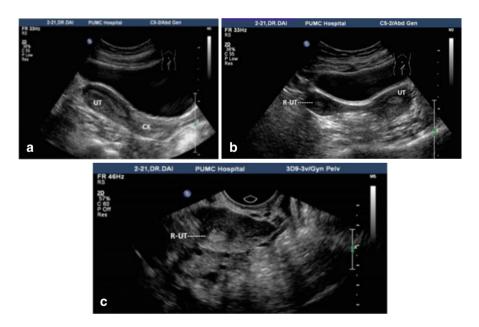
Rudimentary uterine horn. (a) Abdominal ultrasound showing longitudinal uterine image. (b) Abdominal ultrasound showing a cross-sectional image of the uterus and rudimentary uterine horn with a hypoechoic ribbon connecting the horn with the main body of the uterus. (c) Transvaginal ultrasound showing rudimentary horn of the uterus and its endometrial echo (*UT* the body of the uterus palace, *CX* main uterine cervix, *R-UT* rudimentary horn of the uterus)
